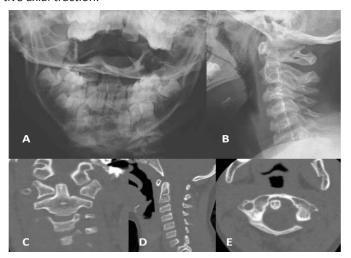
Initial anteroposterior radiograph of the cervical spine indicated loss of symmetry between lateral masses of the atlas and odontoid process (A). Lateral cervical spine radiograph showed loss of the normal lordosis (B). Coronal CT images demonstrated narrowing of the right lateral atlantodental interval and a wider left lateral atlantodental interval (C). Sagittal CT views of the cervical spine indicated no abnormal findings (D). Axial CT views confirmed that the odontoid was lying eccentrically between the lateral masses of the atlas (E).
